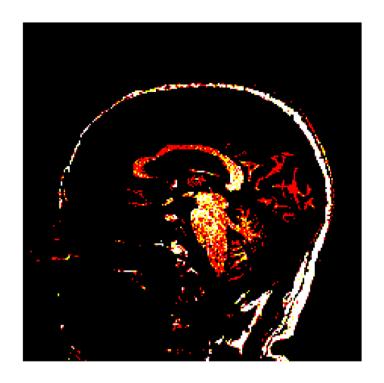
Resnet MRI image
